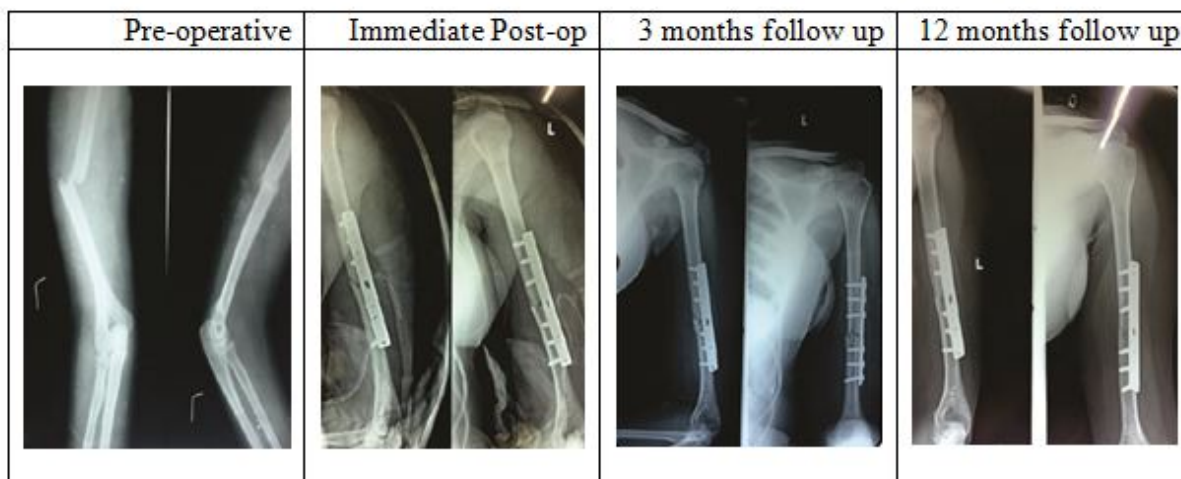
Radiographs of DCP plating for diaphyseal humeral fractures.
